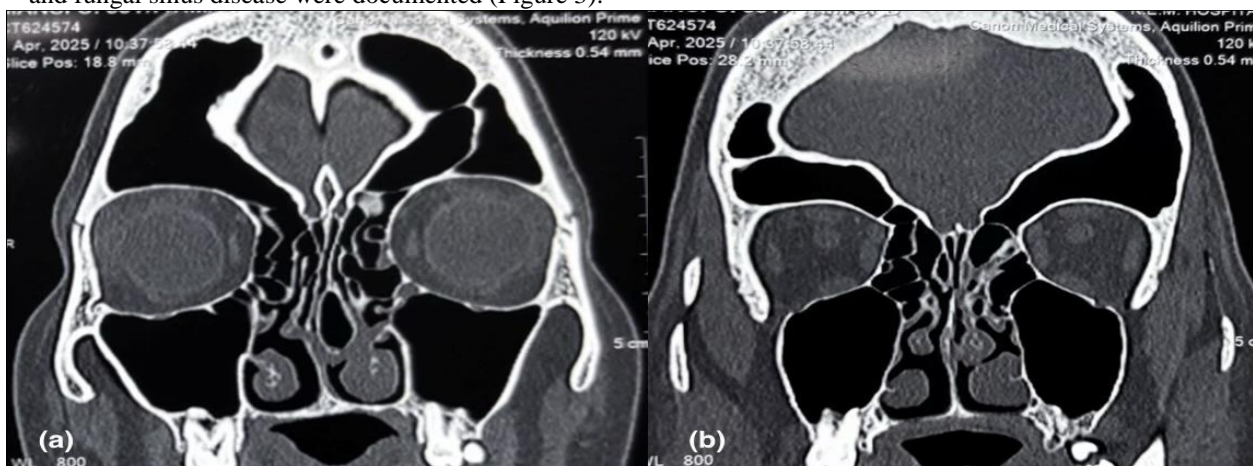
Radiological findings suggestive of Pneumosinus Dilatans. CT-PNS in coronal view showing deviated nasal septum (DNS) to right with left concha bullosa, left inferior turbinate hypertrophy (a) and abnormally enlarged bilateral frontal sinus showing the typical “deer-horn” appearance of frontal pneumosinus dilatans (PSD)(b).
